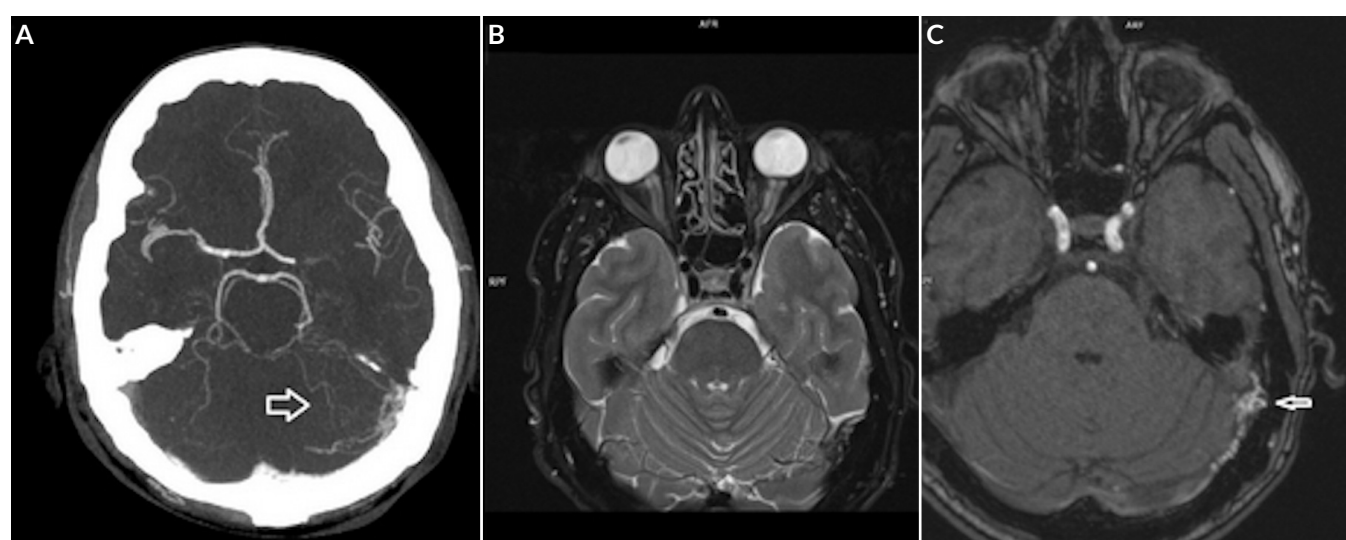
Angio-CT and MR scans. A. Abnormal vessels in the posterior cranial fossa on the left side during an angio-CT examination of cerebral arteries. B. Tortuous course of the optic nerves in a T2-weighted MR image of the orbits. C. Arteriovenous fistula in the posterior cranial fossa in the area of the left sigmoid sinus in a TOF (time of flight) angio-MR image
